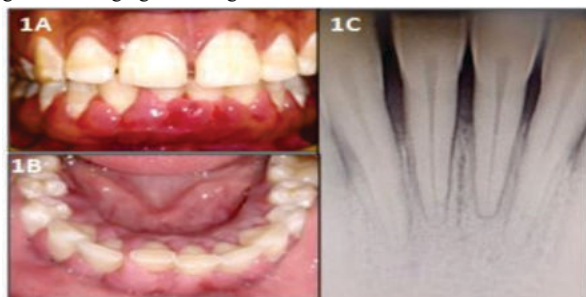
Initial visit pictures and radiograph
